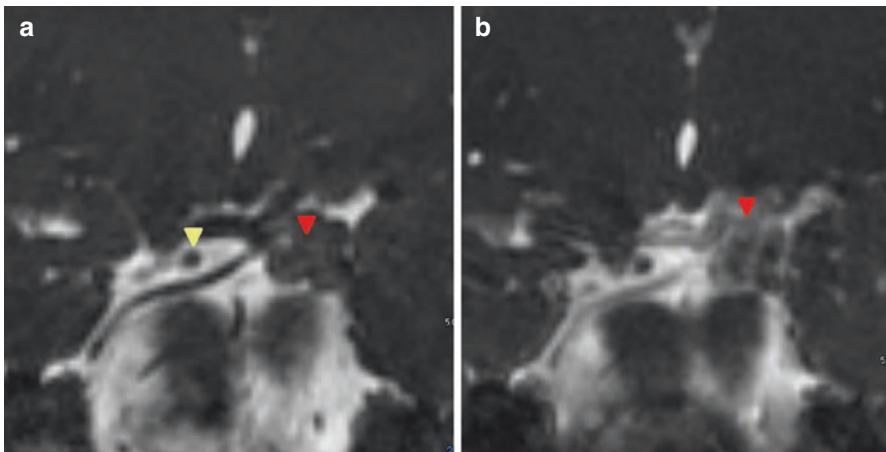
3-T reformatted CISS MRI brain: coronal view of the midbrain demonstrating pre-contrast (a) and post-contrast (b) IIIrd nerve schwannoma with enhancement (red arrowhead). The yellow arrowhead (a) denotes normal IIIrd nerve
